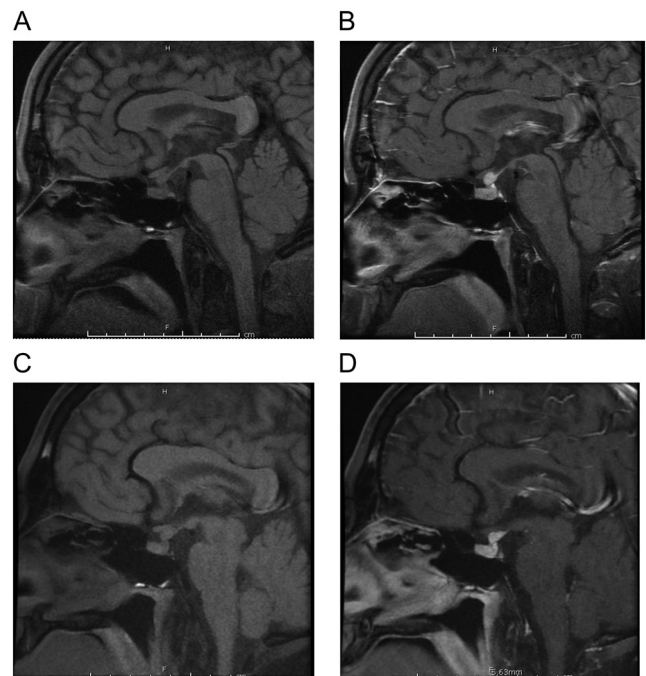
MRI brain. (A) Pre- and (B) post-contrast sagittal MRI brain at diagnosis showing thickened, bulbous enhancement of the pituitary stalk which measures 6.2 × 6.0 × 6.2 mm (AP, trans, SI), (C) pre- and (D) post-contrast sagittal MRI brain 6 months after diagnosis, showing reduction in size of the pituitary stalk, now measuring 4.4 × 4.9 × 5.5 mm.
